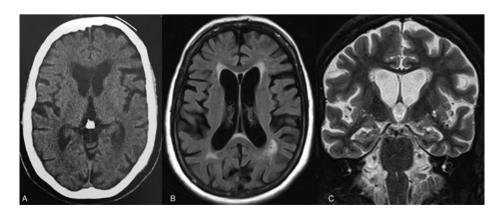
Diffuse cortical atrophy and caudate and lentiform nuclei atrophy with subsequent widening of the frontal horns of the lateral ventricle seen on (A) CT scan of head; (B) MR scan of brain axial FLAIR image and (C) MR scan of brain coronal T2-weighted image. FLAIR, fluid-attenuated inversion recovery.
